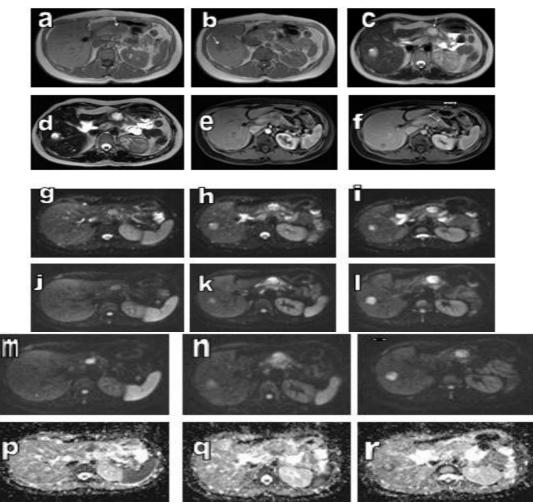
a-b: T1, c-d: T2, T2 SPAIR, e-f:T1 post contrast, g-p: DWI, b:0, 500, 1000, q-s: ADC
